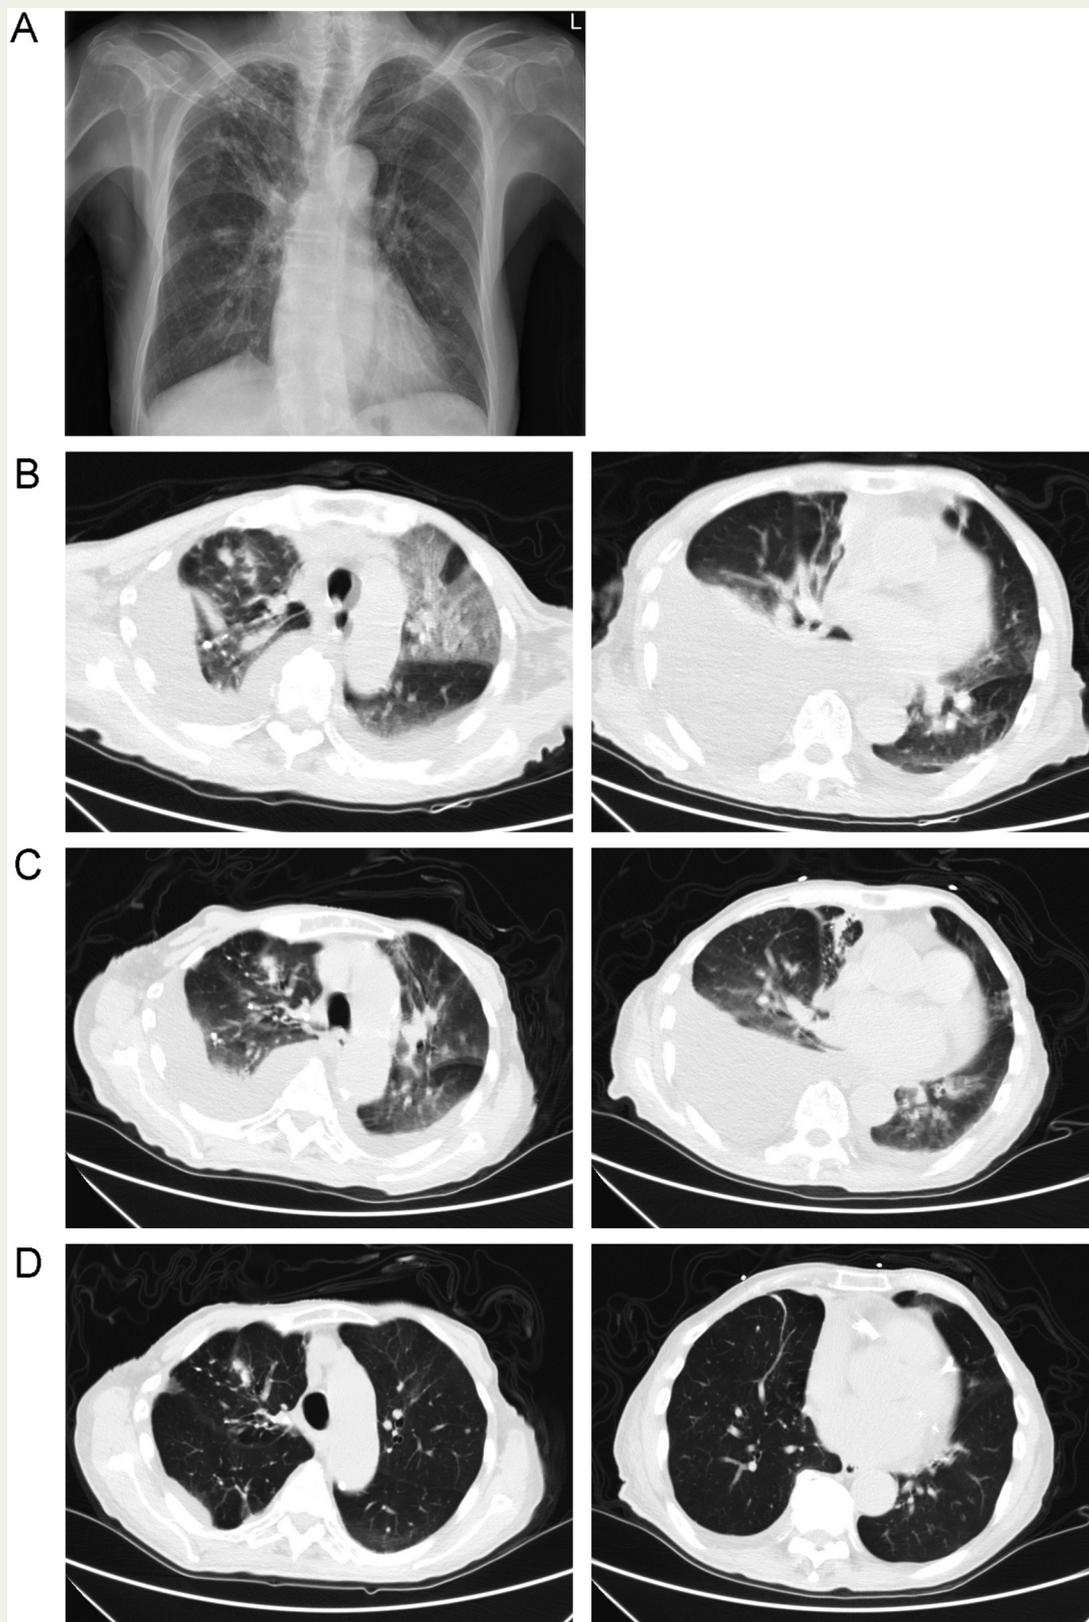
Representative images of the chest X-ray and computed tomography (CT) in case 1 with post cardiac injury syndrome after catheter ablation of atrial fibrillation. (A) Chest X-ray before catheter ablation. (B) CT images one month after the operation showed massive pulmonary infiltrates and pleural effusion. (C) Repeated CT images showed that there was still massive pleural effusion and the pulmonary infiltrates were partially resolved after antibiotic treatment and thoracentesis and chest drain. (D) Two (2) weeks after prednisone treatment and chest drain, the massive pleural effusion and pulmonary infiltrates were completely resolved.
